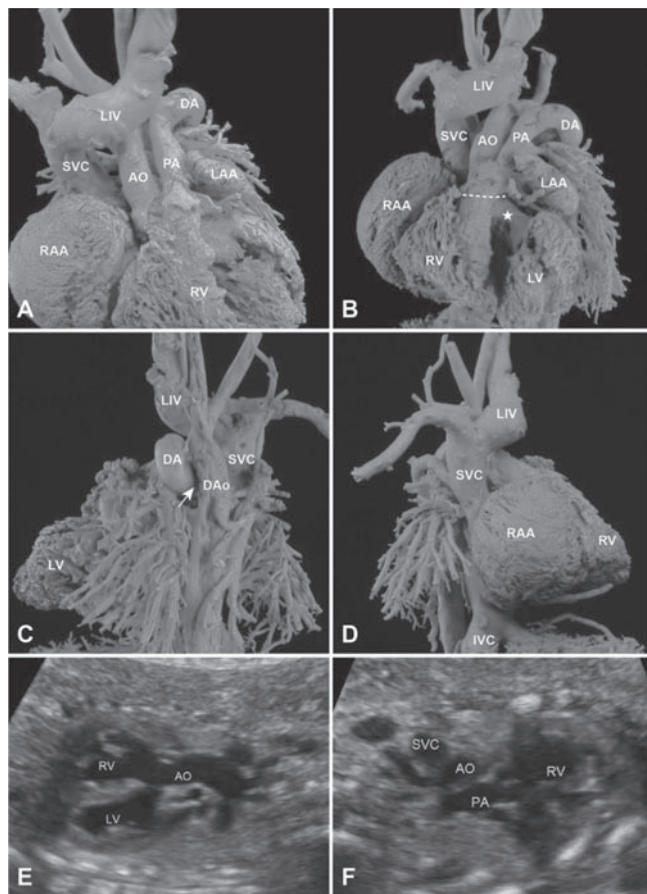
Cast demonstration of a fetus with double-outlet right ventricle (DORV), ventricular septal defect (VSD), dilated and tortuous DA (Case 1). (A) Right anterior 45° view: AO and PA are both originated from right ventricle (RV). (B) Left anterior 45° view: The overriding ratio of aortic root is approximately 80-90%. The dotted line represents the position of aortic root. An abnormal connection between left and right ventricle indicates the existence of a VSD (white asterisk). (C) Posterior view: A dilated and tortuous DA connects PA and the left posterior wall of DAo (white arrow). (D) Right side view: SVC, IVC and LIV connect to right atrium. (E) Prenatal echocardiography showed an overriding aorta (overriding ratio: 80-90%) and a large VSD. (F) Prenatal echocardiography showed PA originated from RV.
